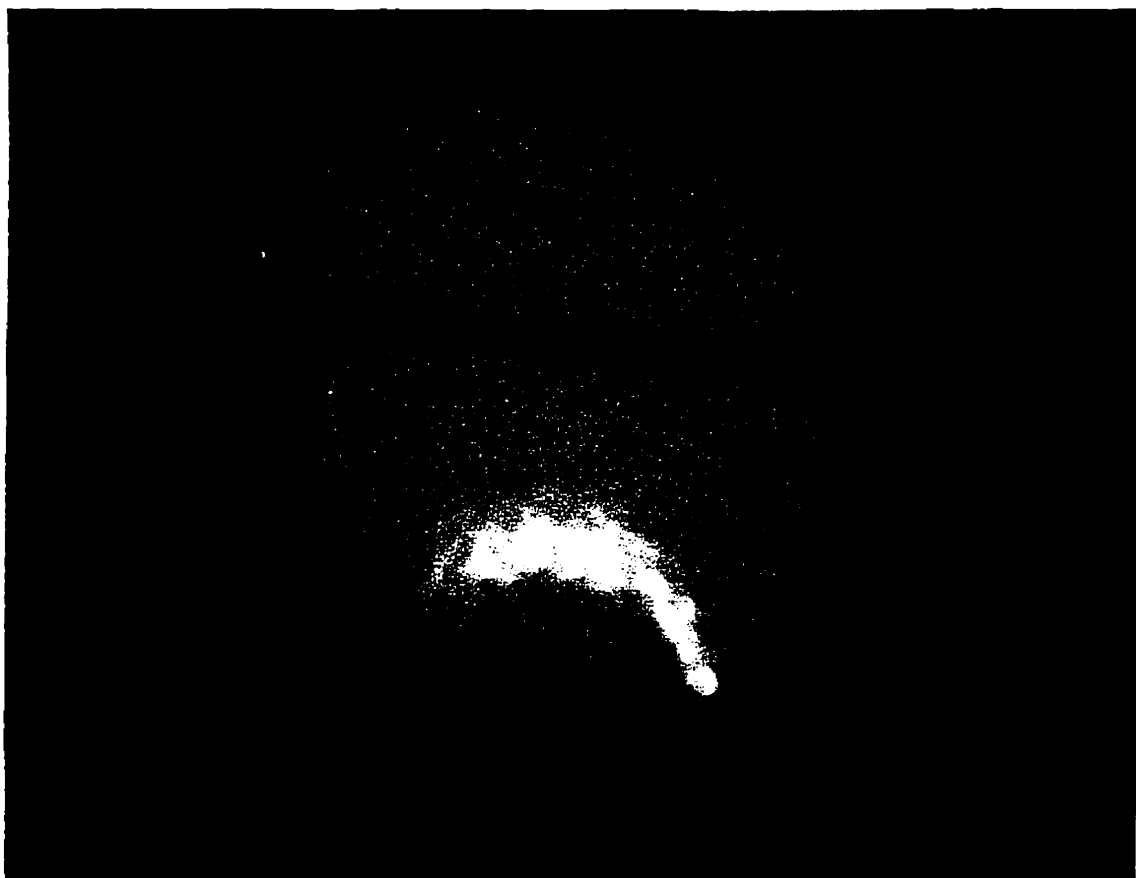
Ultrasound image acquired during measurement of the subglottic lumen. The hyperechogenic air column is marked at the level of the subglottis by the calipers as outlined by the cross-hairs. The accuracy of the digital caliper system is 0.1 mm.
